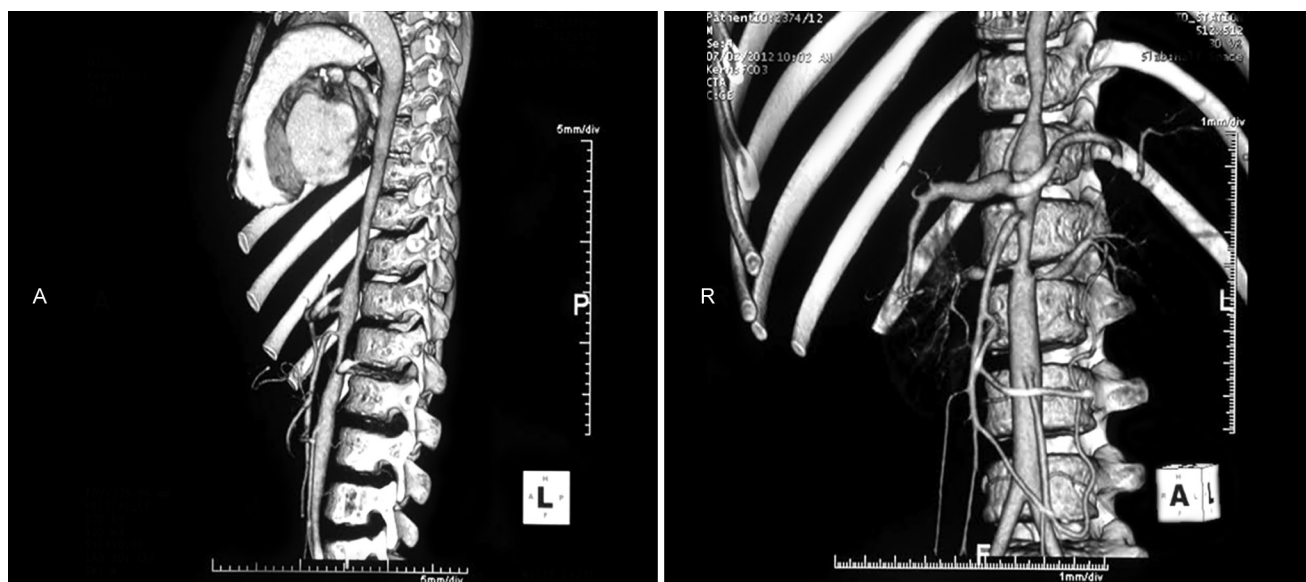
CT angiography showing obstruction of thoracic and abdominal aorta and its branches
